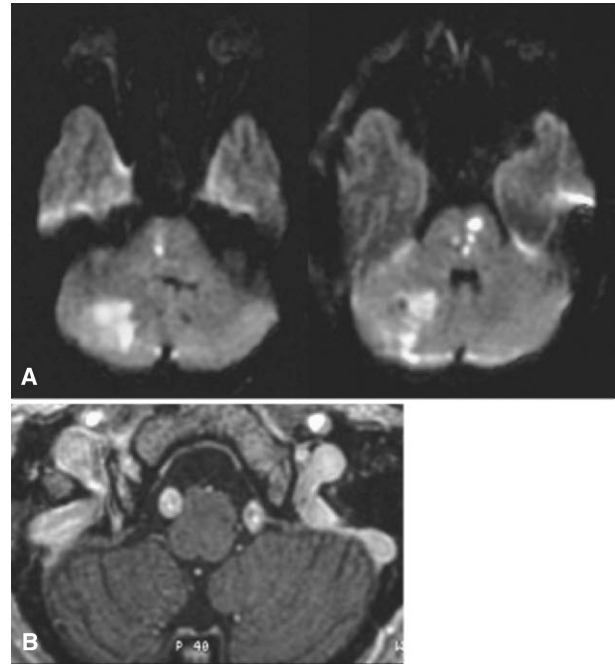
Case 3 MRI on admission showing pontine and cerebellar infarction and double lumen sign on both vertebral arteries
